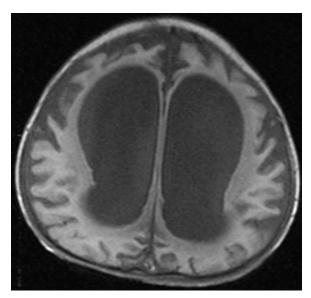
Transverse Cranial MRI of the patient demonstrating hydrocephalus
